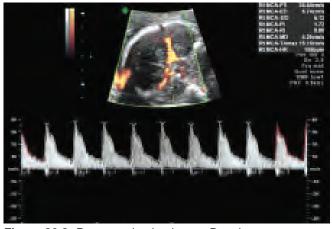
Power and pulsed wave Doppler measurement of the peak systolic velocity of the fetal middle cerebral artery (MCA). The peak systolic velocity (PS) of 34.54 centimeter per second is seen in the box in the upper right. Note the orientation of the MCA is as close to 0° as possible to that of the ultrasound beam
